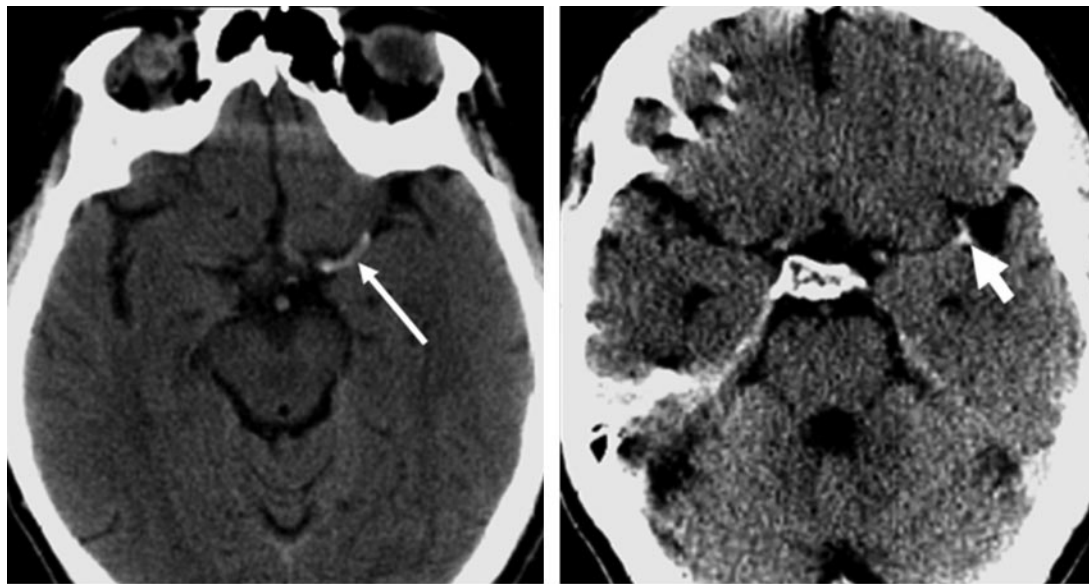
Axial unenhanced CT images in a proximal segment of the left MCA in a 53-year-old man (a) and a distal segment of the left MCA in a 62-year-old woman (b), obtained 2 hours after the onset of right hemiparesis and aphasia, show areas of hyperattenuation (arrow) suggestive of intravascular thrombi.
